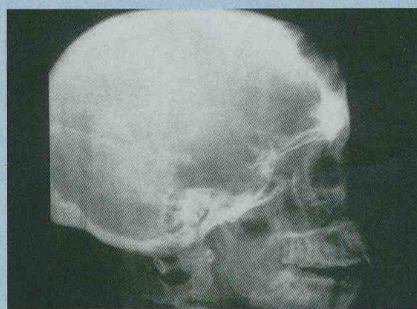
Lateral skull X-ray showing a lytic lesion in the frontal bone.
